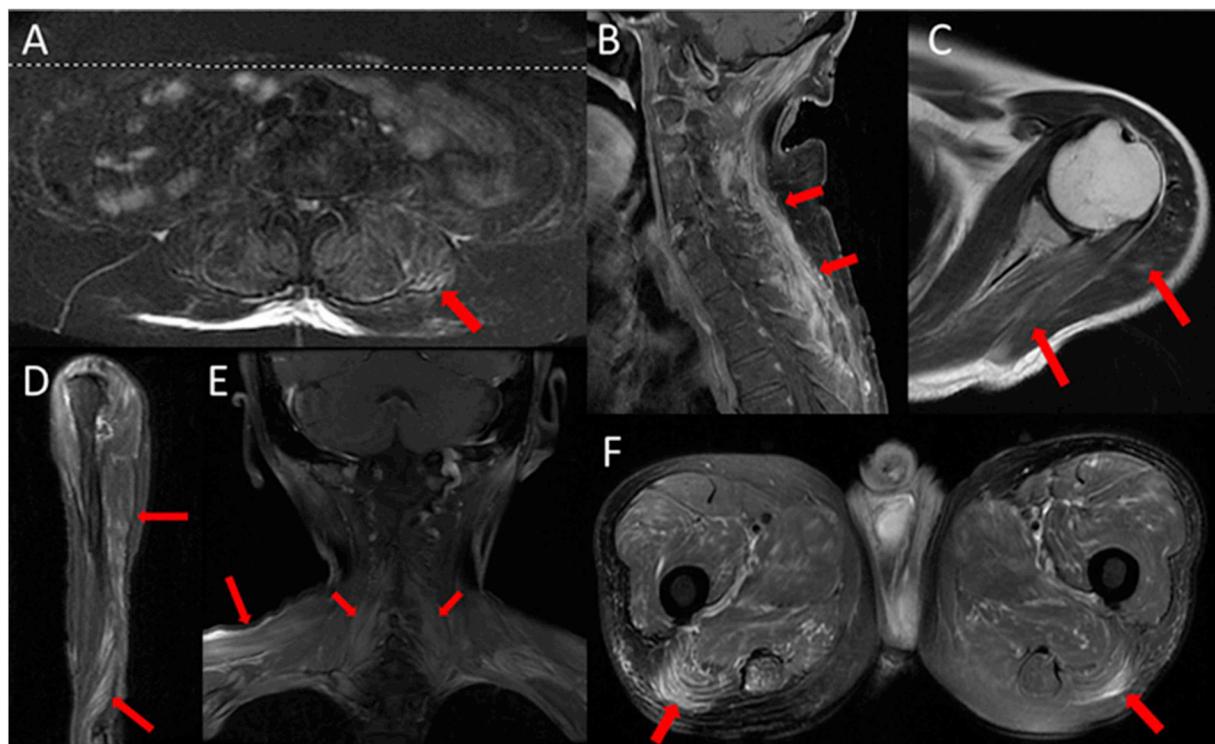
Muscle MRI findings of PD-1 myopathy. Representative MRI obtained from patient 8 (A), patient 10 (B), patient 11 (C–E) and patient 13 (F) show abnormal high intensity signals in the corresponding muscles. (A) Axial fat-suppression T2-weighted image of the paraspinal muscles. (B) Sagittal gadolinium enhancement fat-suppression T1-weighted image of the posterior cervical muscles. (C) Axial T2-weighted image of the shoulder girdle muscles including the supraspinatus, infraspinatus and deltoid muscles. (D) Coronal fat-suppression T2-weighted image of the triceps brachii. (E) Coronal gadolinium enhancement fat-suppression T1-weighted image of the spinal muscles and trapezius. (F) Axial fat-suppression T2-weighted image of the hamstring muscles.
